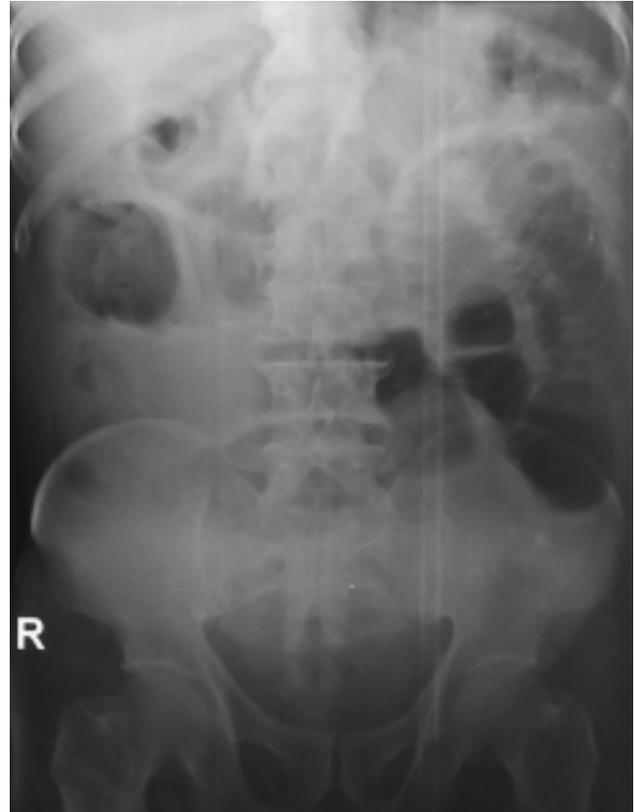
Digital X-ray abdomen AP erect view
